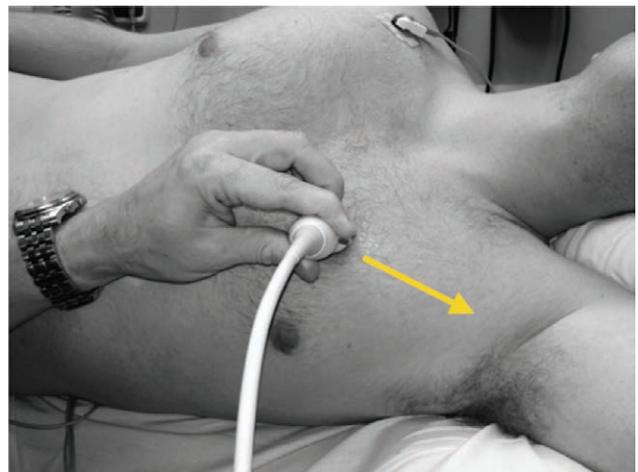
Probe position for the parasternal short axis (PSAX.) The probe is just to the left of the sternum, in the fourth intercostal space (though this location will vary), with the indicator pointing toward the patient's left shoulder. The indicator location and direction is shown by the yellow arrow.
